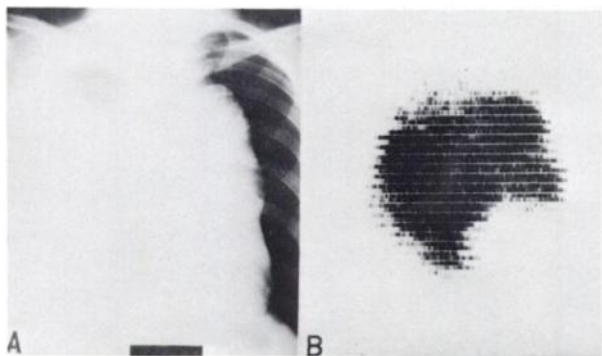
(A) Chest x-ray shows large mediastinal shadow and right hydrothorax. (B) Scintigram is strongly positive.
